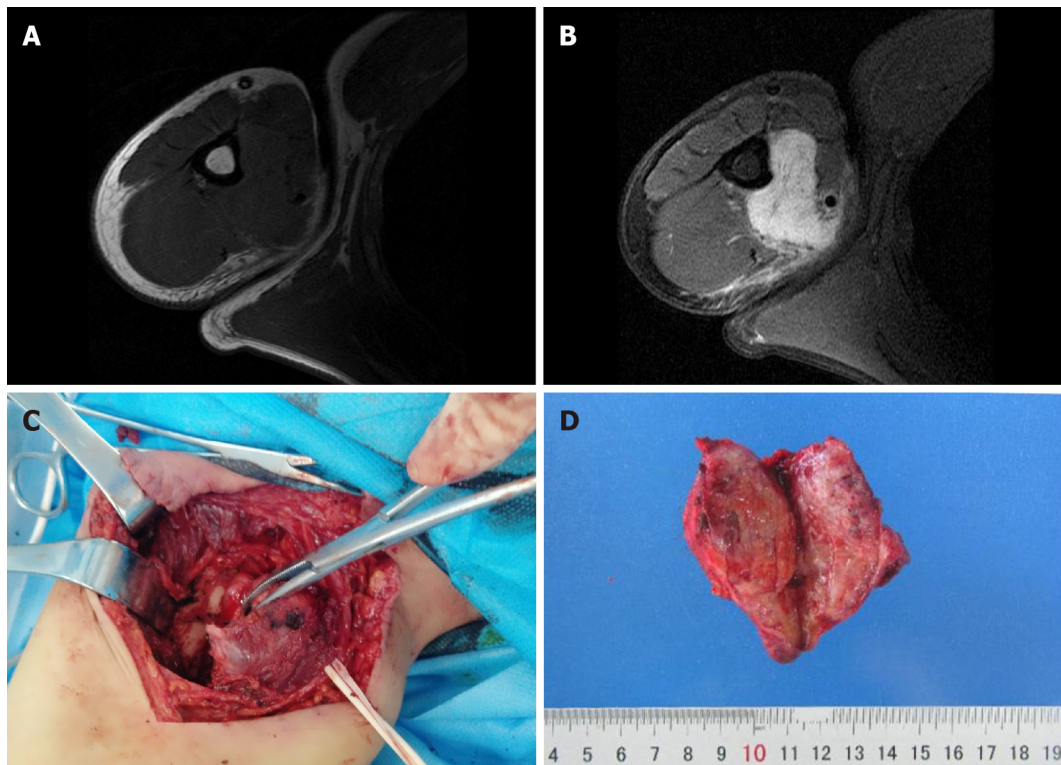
Imaging and gross examination. A: Magnetic resonance imaging showed patchy low signal in the medial humerus (T1WI); B: Magnetic resonance imaging showed a high signal intensity on the humerus, with local thinning of the humeral cortex (T2WI); C: The root of the mass extended laterally below the biceps brachii and was closely related to the humerus; D: The mass was nodular, with a diameter of 7.5 cm, a relatively clear boundary, and a reddish gray appearance on cross section.
